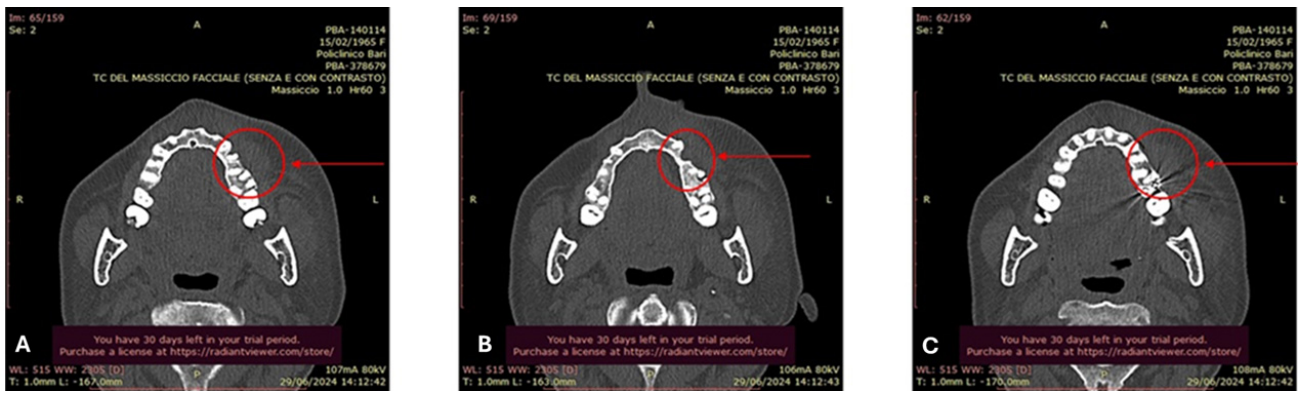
Axial CT images of the facial bones taken on 29 June 2024, showing soft tissue involvement following apical extrusion of sodium hypochlorite from tooth 2.3. (A) Axial slice showing soft tissue swelling in the left maxillary region, with evident asymmetry compared to the contralateral side (red circle). (B) Enlargement of the periapical region of tooth 2.3, with disruption of trabecular bone pattern and edema extending into adjacent soft tissues (red circle). (C) Continued visualization of the inflammatory process involving the left infraorbital area, consistent with diffusion of irrigant through fascial planes (red circle). L, left; R, right.
